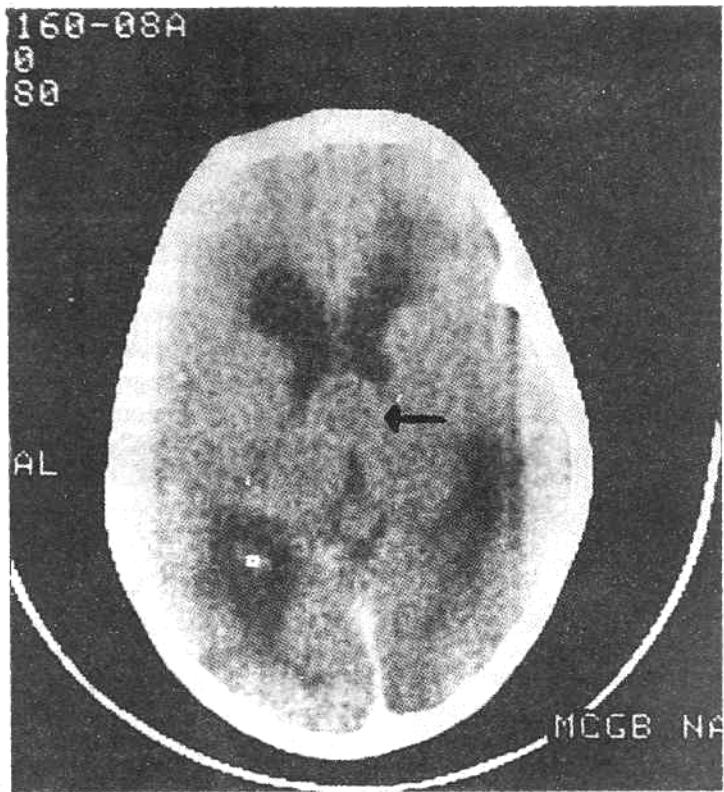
Enhanced CT Scan showing minimal ring enhancement with an isodense cyst in Case 1.
